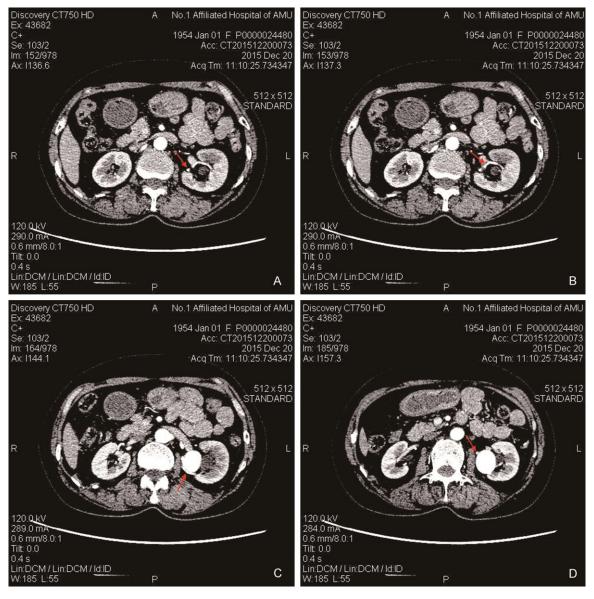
Preoperative contrast enhanced computed tomography revealed the left RAA which consist of four bifurcation located in the renal hilum and left renal pelvis stones. A: The first bifurcation. B: The second bifurcation. C: The third bifurcation. D: The fourth bifurcation.
